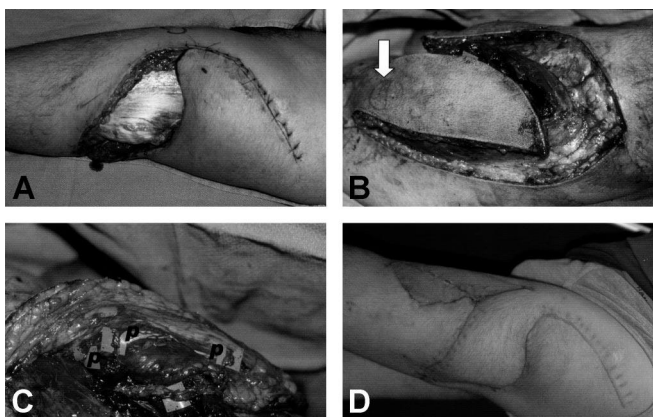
A, Deep gouge of the lateral left thigh exposing the fascia lata, with the more proximal open femur fracture tenuously covered with buttock tissues; B, elevated local anterolateral thigh flap, with a perforator that had been marked preoperatively (arrow) after identification using an audible Doppler; C, elevated flap, with microgrid under 3 perforators that were included; D, final healed wound. Note skin graft was necessary at the anterior thigh donor site.
